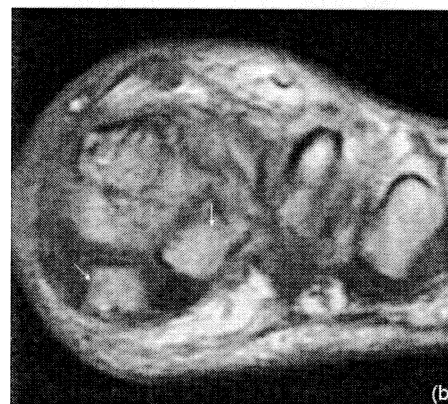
T1-weighted, fast spin-echo MR image in the axial (a), coronal (b) and sagittal (c) plane of a 53-year-old woman with osteoarthritis of the I.MTP joint and a moderate bone marrow edema in both sesamoids (arrows) after surgery because of hallux valgus.
